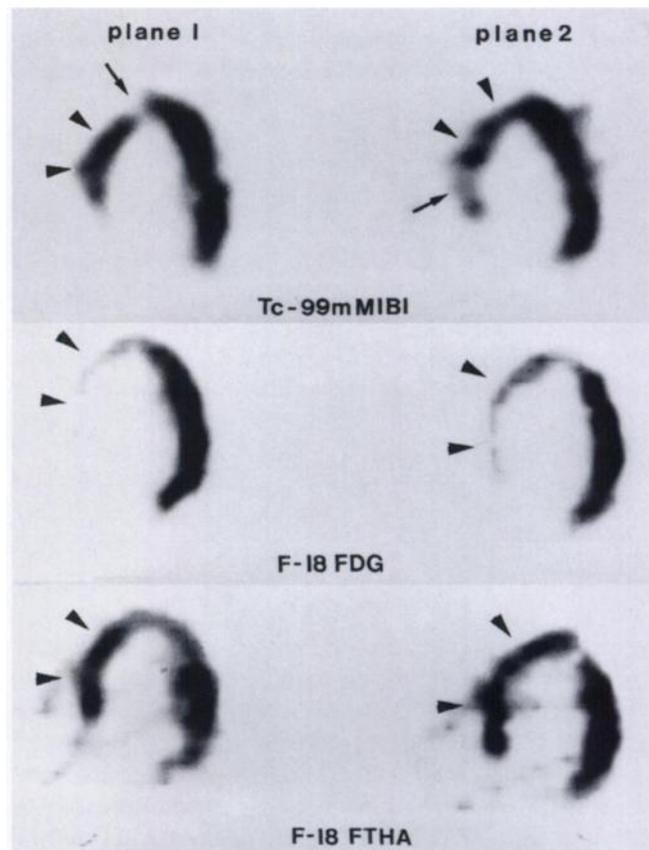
Myocardial uptake of ^{99m}Tc -MIBI, [^{18}F]FDG and [^{18}F]FTHA is displayed in two midventricular horizontal long-axis planes. Reduction of septal ^{99m}Tc -MIBI uptake is noted in only two small areas (arrows). Despite preserved ^{99m}Tc -MIBI uptake in large parts of the interventricular septum (arrowheads) and maintained septal [^{18}F]FTHA uptake (arrowheads) [^{18}F]FDG uptake is severely reduced in the entire septum (arrowheads), suggesting scarred myocardium.
